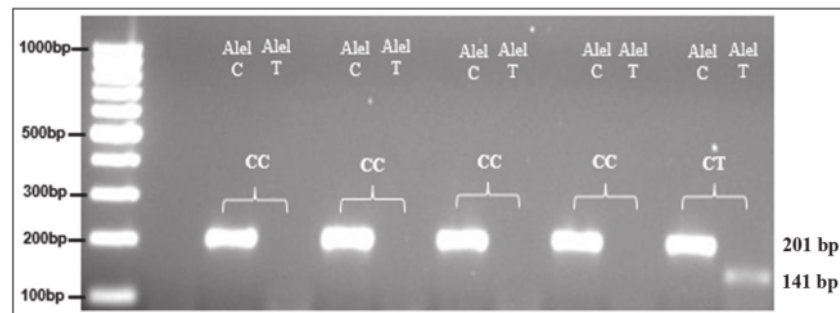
Visualization of DNA amplicon (patient with schizophrenia) in CTLA-4 rs5742909 gene with CC and CT genotypes after primer separation
